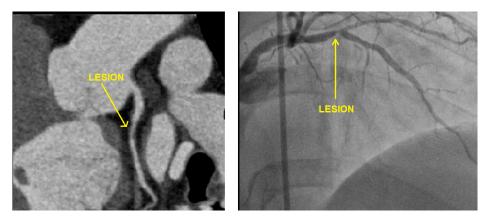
Plaque visualization in CT-Scan(left) and in Invasive Coronary Angiography(right) in Cath-Lab.
